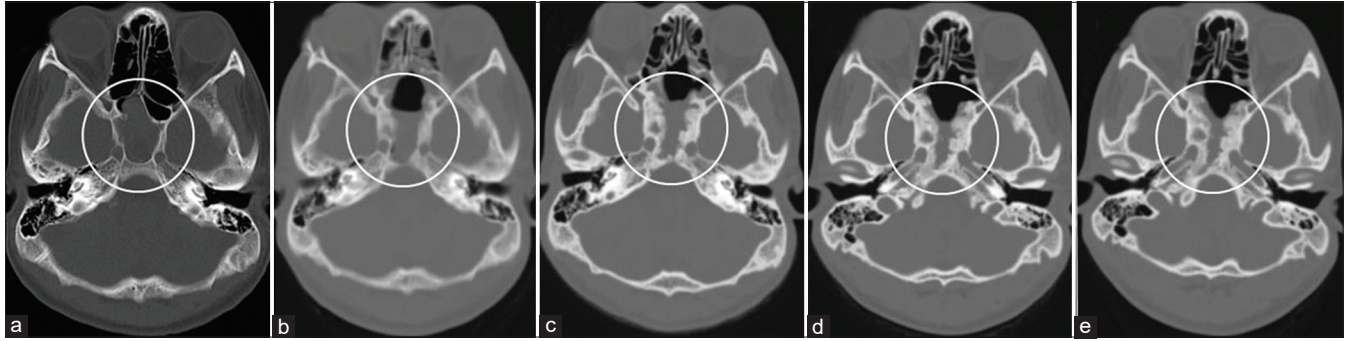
CT scans at preoperative (a), 2 years after the initiation of the denosumab treatment (b), a year after extending the dosing interval of denosumab to 4 monthly (c), and a year (d) and 2 years (e) after extending the dosing interval of denosumab to 6 monthly.
